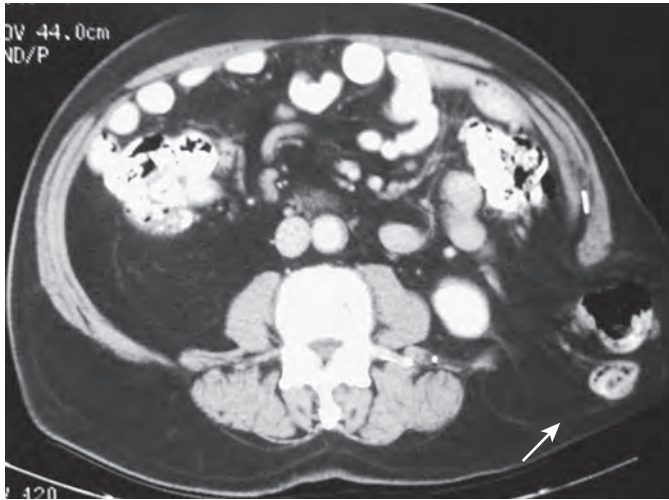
Lumbar hernia. CT shows the descending colon and mesentery herniating (arrow) posterolaterally through the left inferior lumbar space or Petit's triangle.
